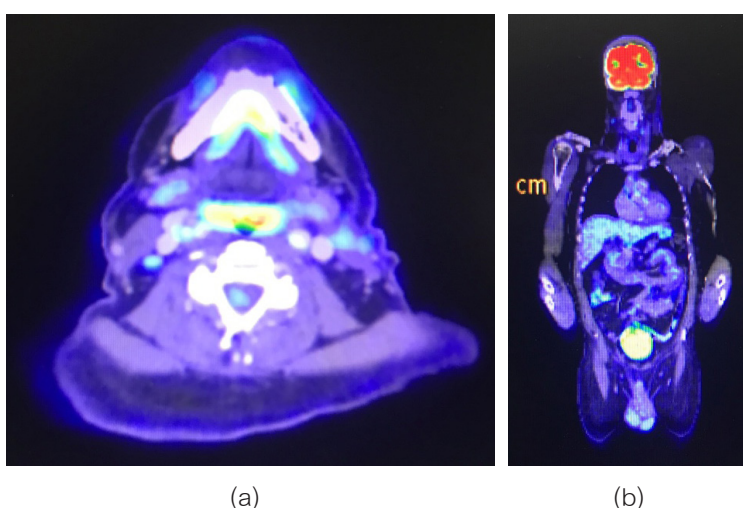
(a) PET-CT examination showed area of FDG uptake at right cervical lymph node(level IIb), highly suspicious of metastasis (b) no definite abnormal lesion or other distant metastasis.
